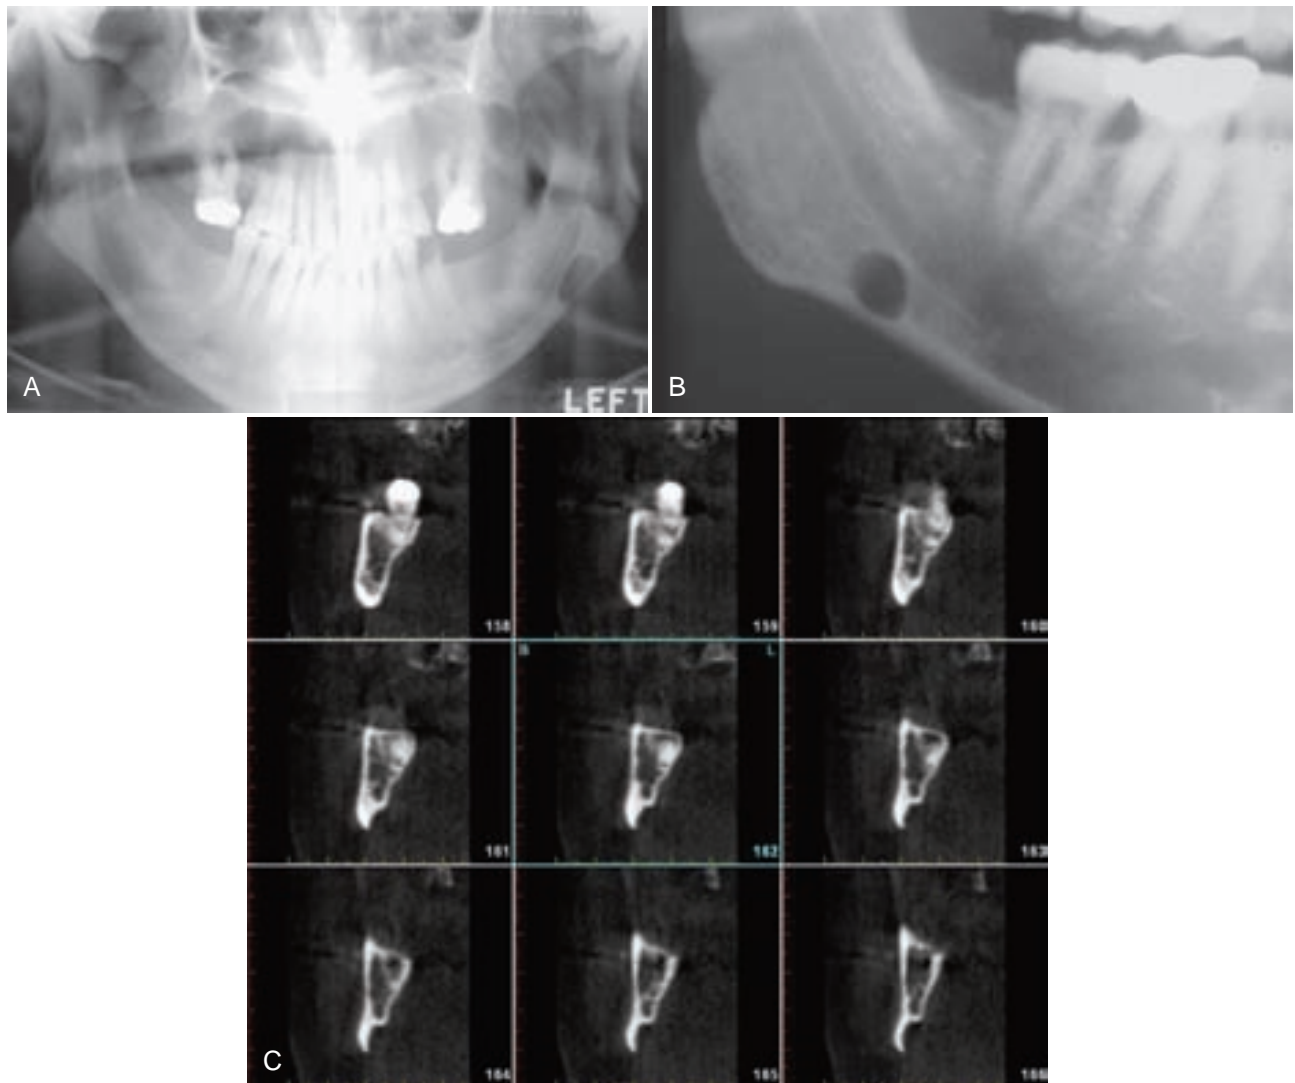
Stafne bone cavity. A, Circumscribed radiolucency at the inferior border of the mandible, beneath the inferior alveolar canal. B, Circumscribed radiolucency beneath the inferior alveolar canal. C, CT scans show lingual depression just beneath inferior alveolar canal. (A and C, Courtesy of Dr. Bernard Friedland, Harvard School of Dental Medicine, Boston, Mass; B, Courtesy of Dr. George Wysocki, London, Ontario, Canada.)
